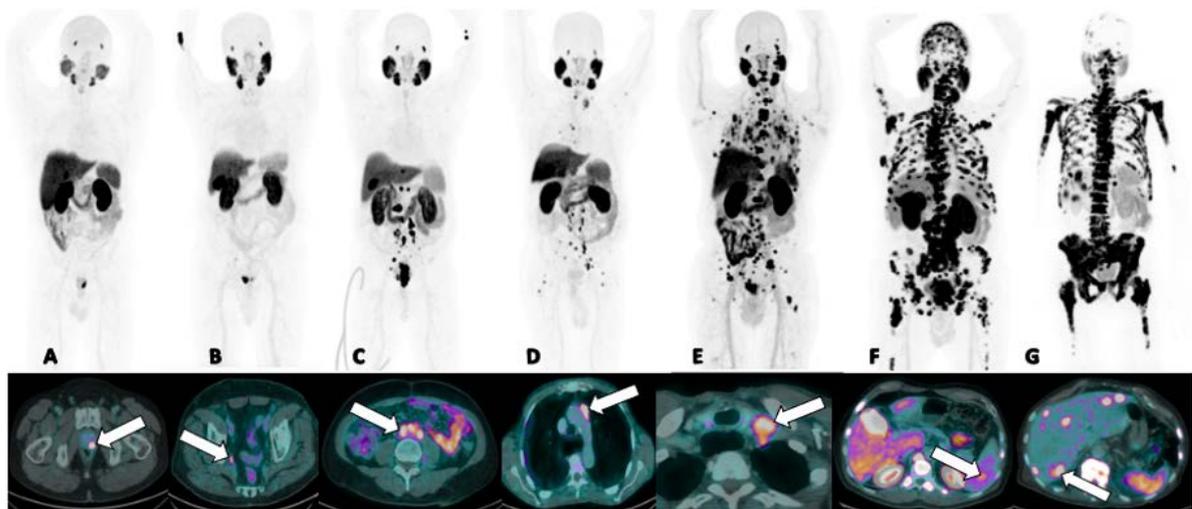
PET images with ^{18}F -PSMA in anterior MIP and fusion in axial section with uptake in (A) focal in prostate (B) prostate with right iliac ganglion (C) prostate with pelvic and retroperitoneal lymphadenopathy (D) multiple bilateral inguinal, pelvic, retroperitoneal, mediastinal and cervical lymphadenopathy (E) prostate, pelvic, retroperitoneal, mediastinal, cervical, axillary lymph nodes, pulmonary nodules, and multiple bone metastases in the axial and appendicular skeleton (F) prostate, pelvic, retroperitoneal, cervical, axillary, pulmonary nodules, multiple bone metastases in axial and appendicular skeleton in the spleen. Is to notice the absence in the uptake of the right submaxillary glandular. (G) prostate, pelvic and retroperitoneal lymphadenopathy, extensive bone metastases in the axial and appendicular skeleton (super scan) and liver metastasis.
